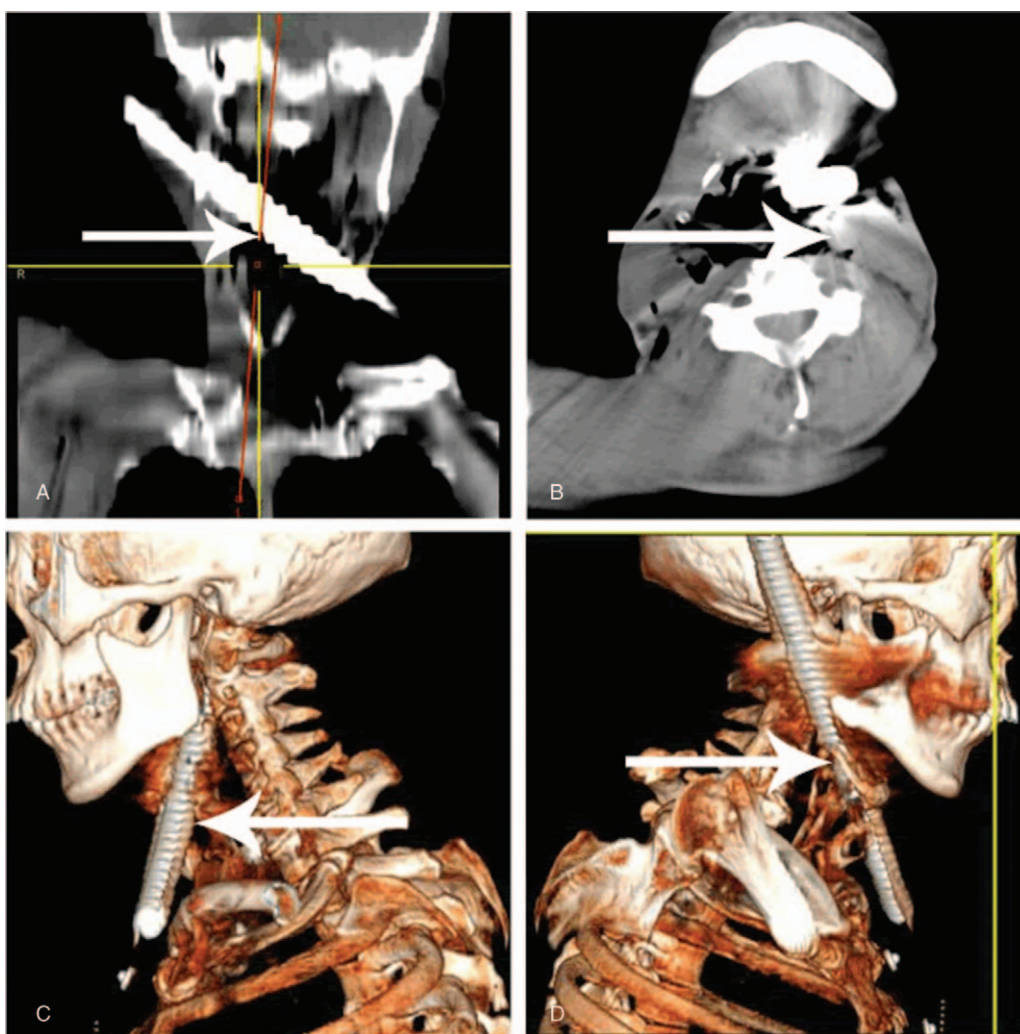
Computed tomography (CT) and three-dimensional reconstruction of the CT images of neck. (A) CT showed a rod-shaped metallic foreign body protruding from both sides of the neck and the foreign body headed diagonally across the oropharynx. (B) CT showed the relationship between major vessels (arrow) and the rebar. (C and D) Three-dimensional reconstruction of the CT images showed the track of metallic foreign body, and that it passed through the hyoid bone region (arrow). CT = computed tomography.
